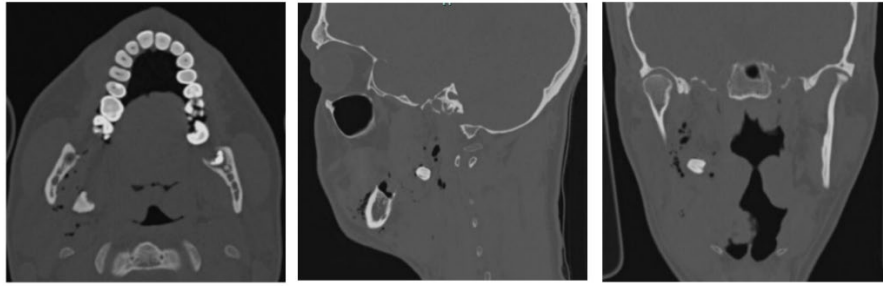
CT scan showing the displaced tooth in ITF (axial, sagittal, and coronal projections).
